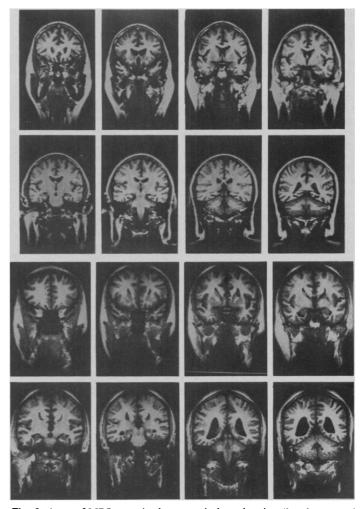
A set of MRI scans in the coronal plane showing (top two rows) normal structure in a normal volunteer and (lower two rows) an abnormal scan from a patient with schizophrenia and nearly complete agenesis of the corpus callosum. In the abnormal scan, temporal lobes are also distorted, and the posterior ventricular horns are markedly enlarged.
